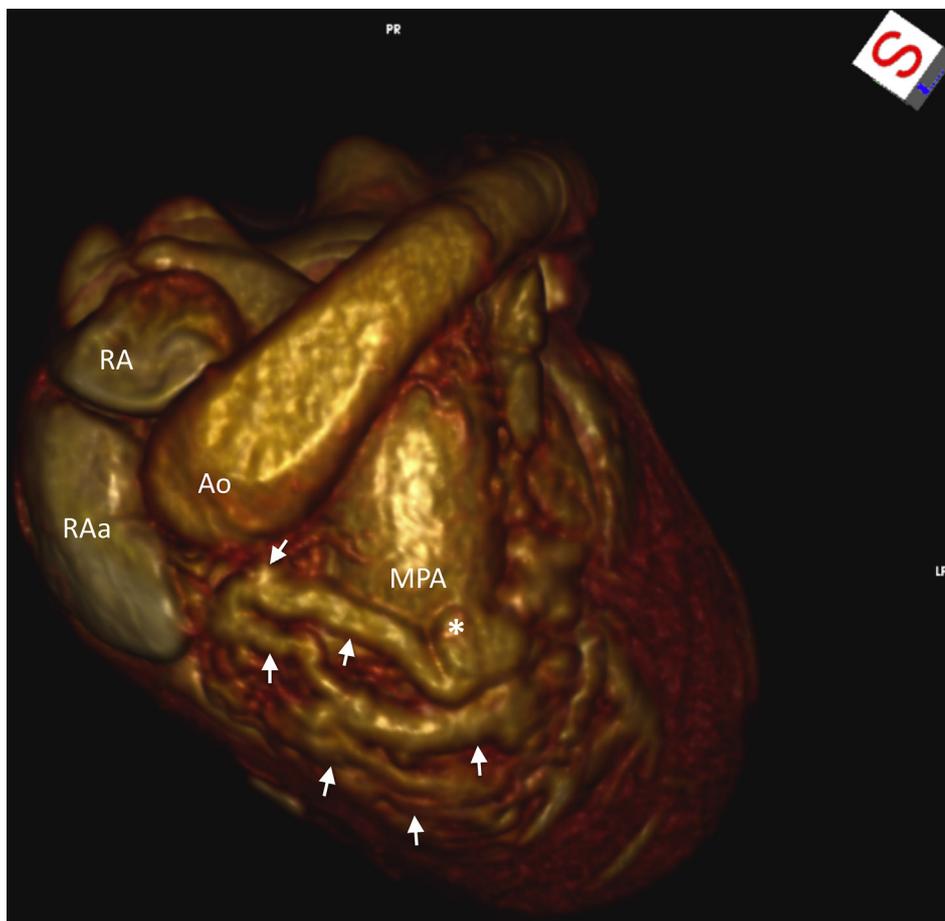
Three-dimensional multiplanar reconstructed CT image of the heart from the cranial aspect showing the aberrant coronary vessel (arrows) feeding into the pulmonary artery (asterisk). Abbreviations: Ao, aorta; RA, right atrium; RAa, right auricular appendage; MPA, main pulmonary artery.
